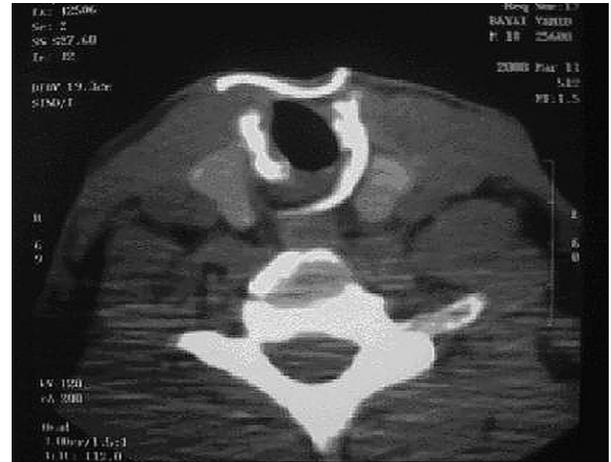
Axial subglottic computed tomography scans showing titanium membrane as anterior wall of the airway.
